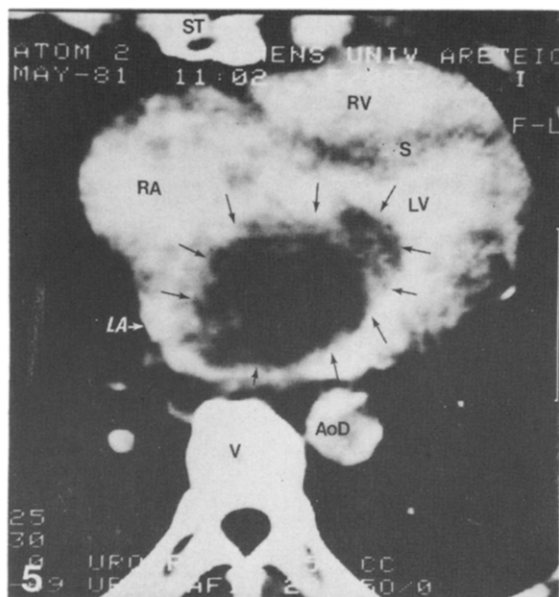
Case No. 5: patient with a left atrial myxoma (?). CT scanning demonstrates a dilated left atrial cavity filled with a low density mass (arrows).
